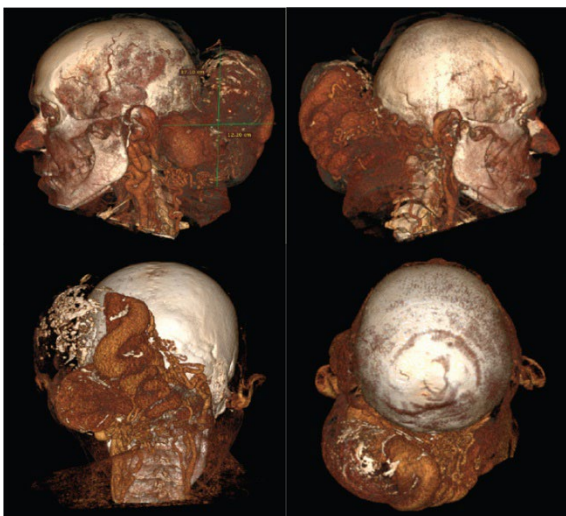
Computed tomography angiograms of the neck and head of patient M. upon admission to hospital, 3D reconstruction. A giant extra-intracranial arteriovenous malformation of the cervicoccipital region
